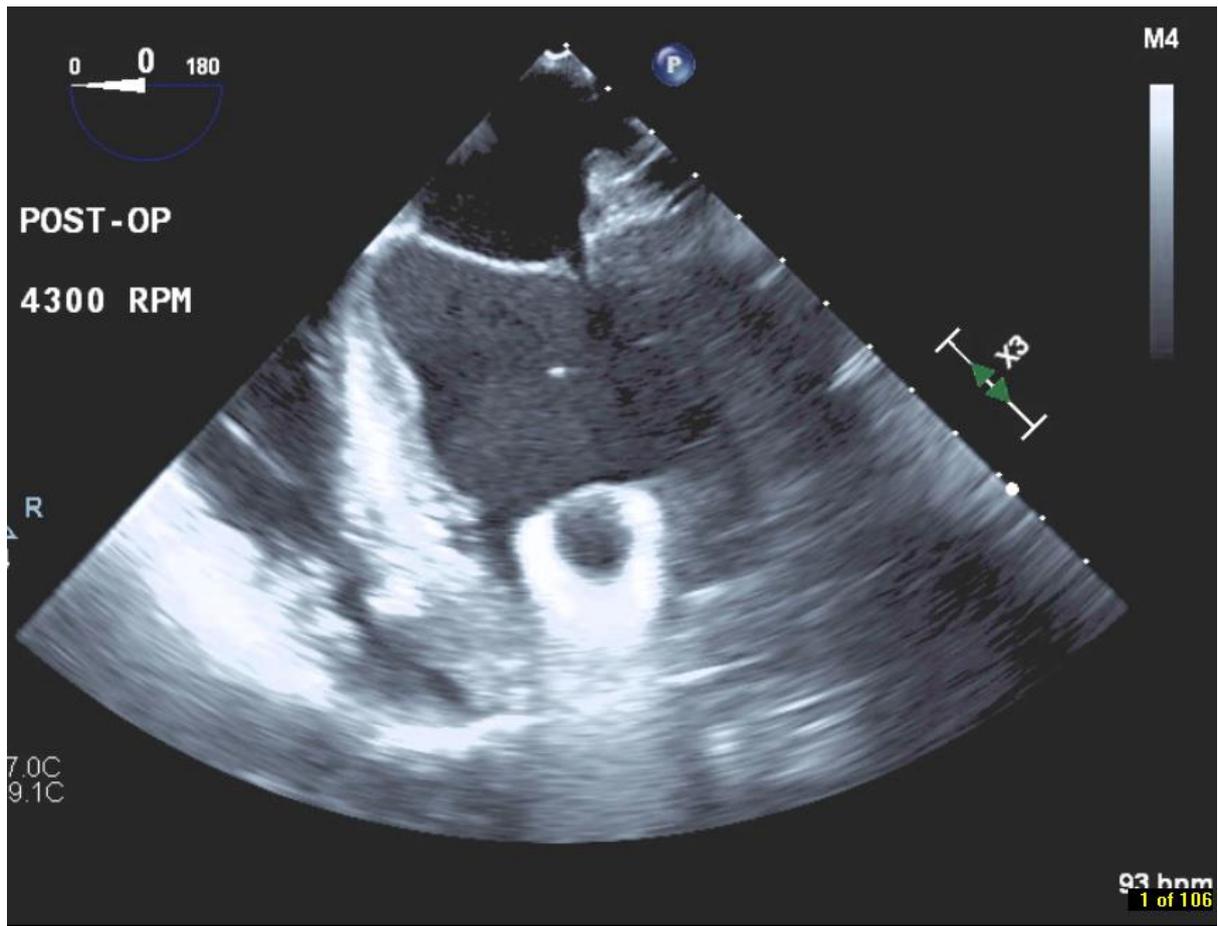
A post-operative tran-esophageal echocardiography showing the relation of LVAD internal orifice in relation to the left ventricular cavity.
